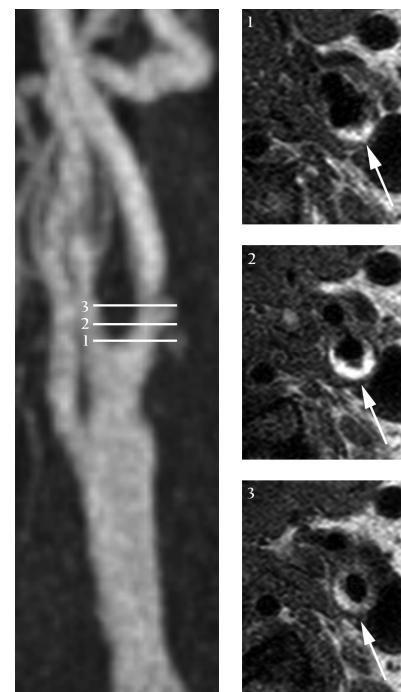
CEMRA image (left) with 50-69% stenosis; hyperintense plaque (arrows) in ICA on T₁w-TFE MRI (right)
